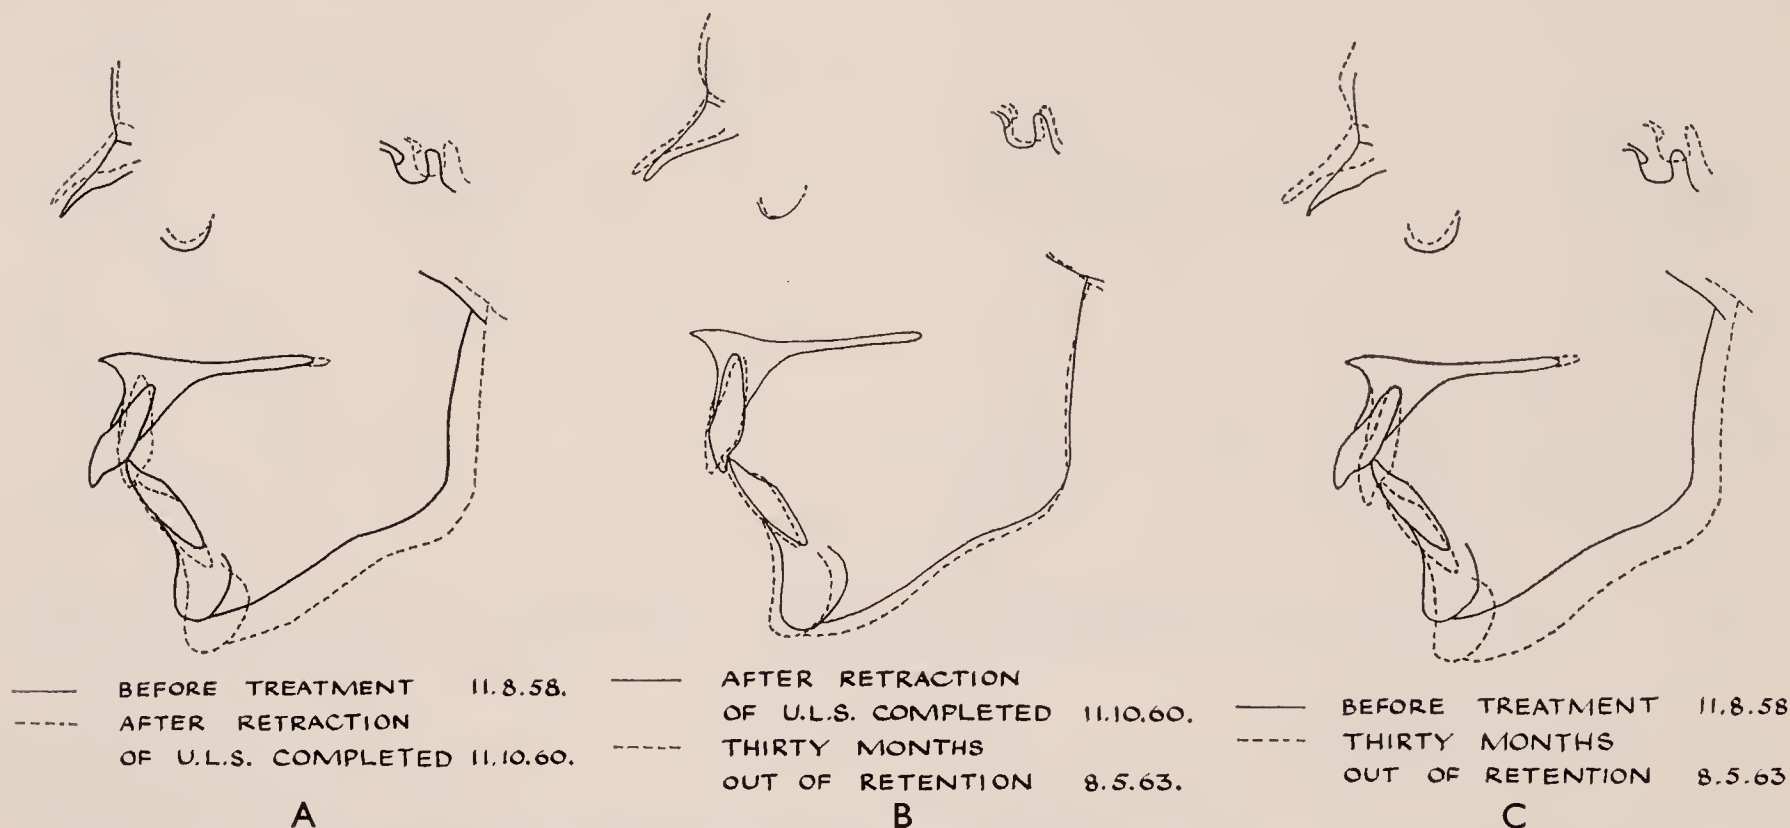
Tracings of lateral skull radiographs of Patient D.G., superimposed on ANS and maxillary plane, showing changes in upper incisors. A, During treatment. B, Immediately following treatment. C, Overall.
